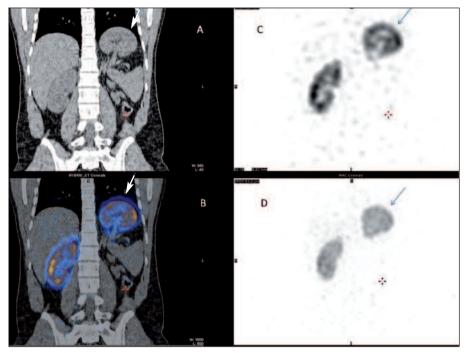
Coronal slices of Tc99m-DMSA SPECT/CT (A:CT, B:fusion, C:SPECT, D:SPECT-MIP images) localized left kidney exactly in left thorax (arrow).
